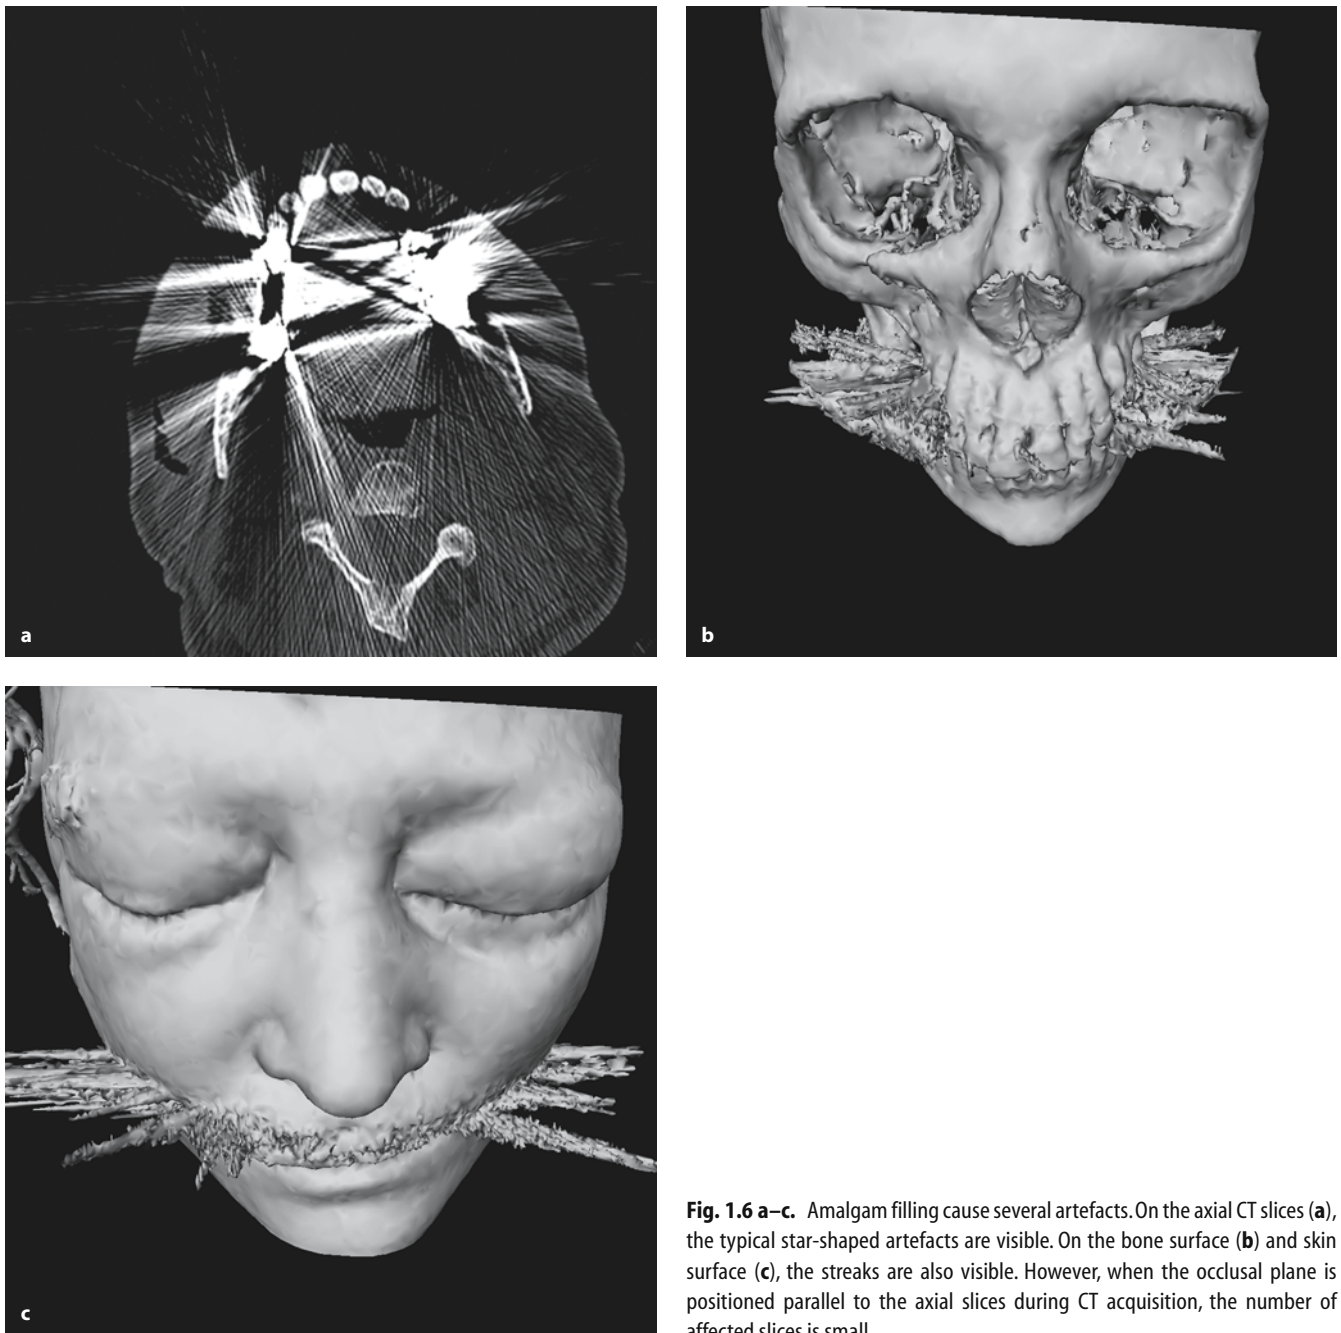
a–c. Amalgam filling cause several artefacts. On the axial CT slices (a), the typical star-shaped artefacts are visible. On the bone surface (b) and skin surface (c), the streaks are also visible. However, when the occlusal plane is positioned parallel to the axial slices during CT acquisition, the number of affected slices is small
